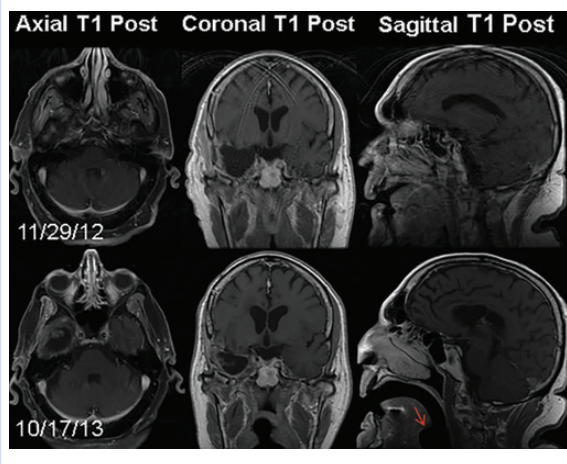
Serial magnetic resonance imaging (MRI) studies (axial, coronal, and sagittal T1-weighted postcontrast imaging) of the same patient. The study on the top row is without an airway device and had a score of 12 out of 30, whereas the study on the bottom row is with a supraglottic airway (LMA Unique™; arrow) and had a score of 27.
